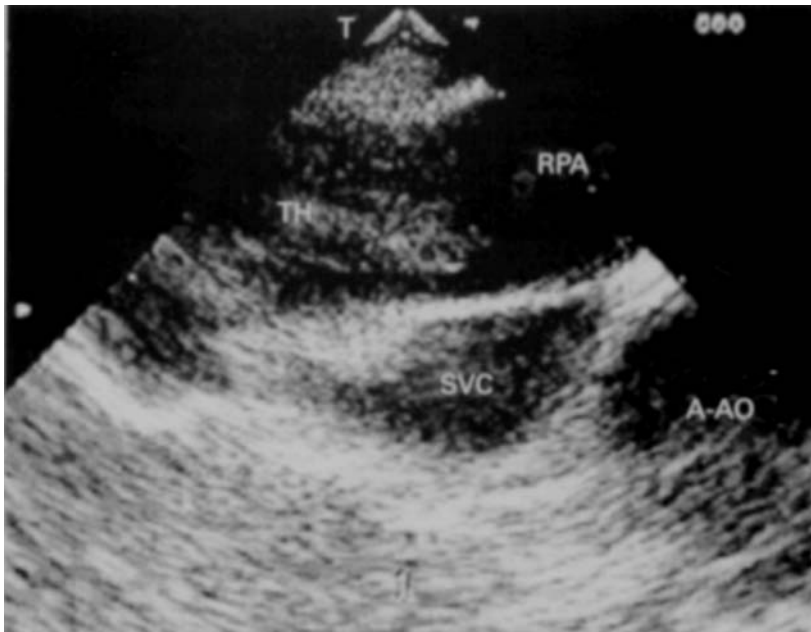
Transoesophageal echocardiogram showing pulmonary embolism. A-AO = ascending aorta, RPA = right pulmonary artery, SVC = superior vena cava, TH = thrombus.
